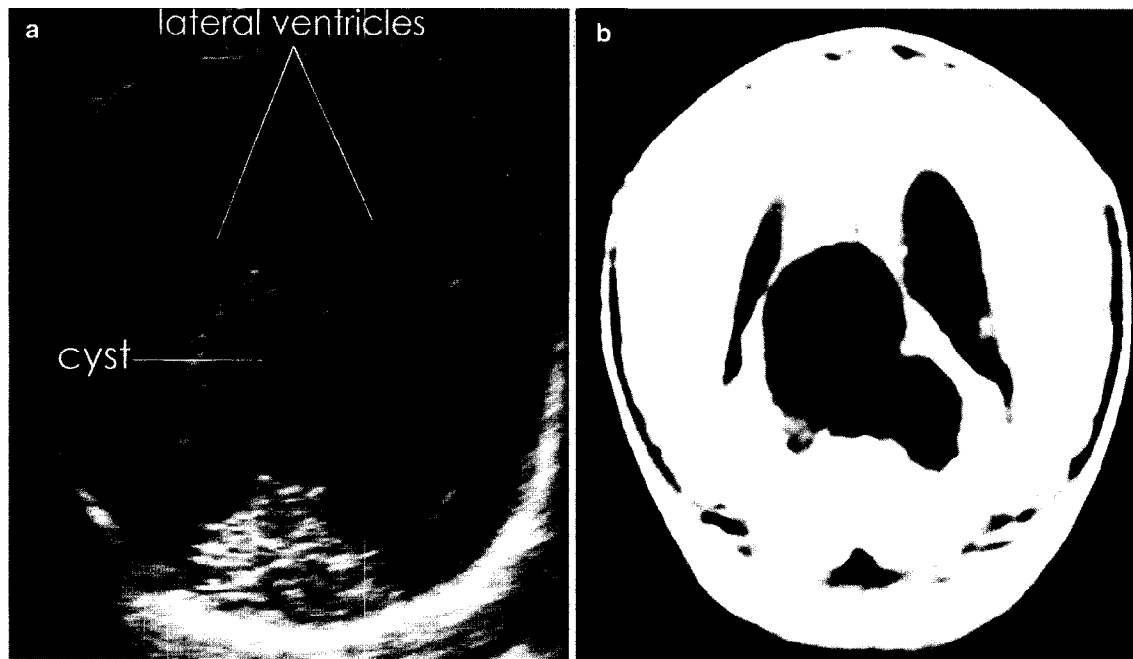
Case 5: coronal scan (a) of a midline arachnoid cyst obtained with transabdominal sonography, compared with the postnatal magnetic resonance image (b). A thin septum is seen within the cyst. It is of note that there was spontaneous regression of ventriculomegaly throughout gestation. The infant was asymptomatic at birth and no surgical treatment was performed
